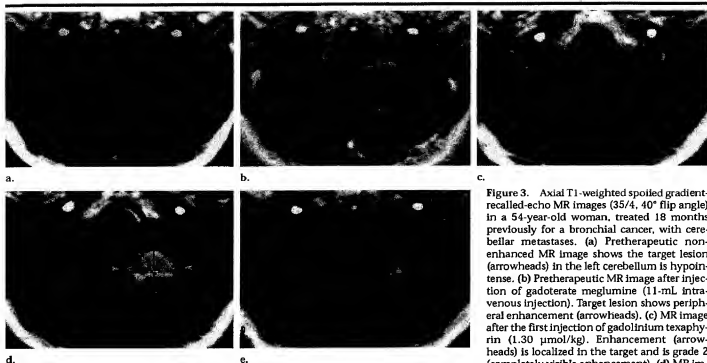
Axial T1-weighted spoiled gradient-recalled-echo MR images (35/4, 40° flip angle) in a 54-year-old woman, treated 18 months previously for a bronchial cancer, with cerebellar metastases. (a) Pretherapeutic non-enhanced MR image shows the target lesion (arrowheads) in the left cerebellum is hypointense. (b) Pretherapeutic MR image after injection of gadoterate meglumine (11-mL intravenous injection). Target lesion shows peripheral enhancement (arrowheads). (c) MR image after the first injection of gadolinium texaphyrin (1.30 $\mu\text{mol/kg}$). Enhancement (arrowheads) is localized in the target and is grade 2 (completely visible enhancement). (d) MR image after the 10th injection of gadolinium texaphyrin. Enhancement (arrowheads) is higher and is grade 3 (high enhancement). 1 and 2 are the two largest perpendicular diameters of the lesion. (e) MR image 56 days after the first gadolinium texaphyrin injection, without injection of contrast agent. Enhancement (arrowheads) is still well visible and is grade 2. Tumor decreased to 65% of initial size.
